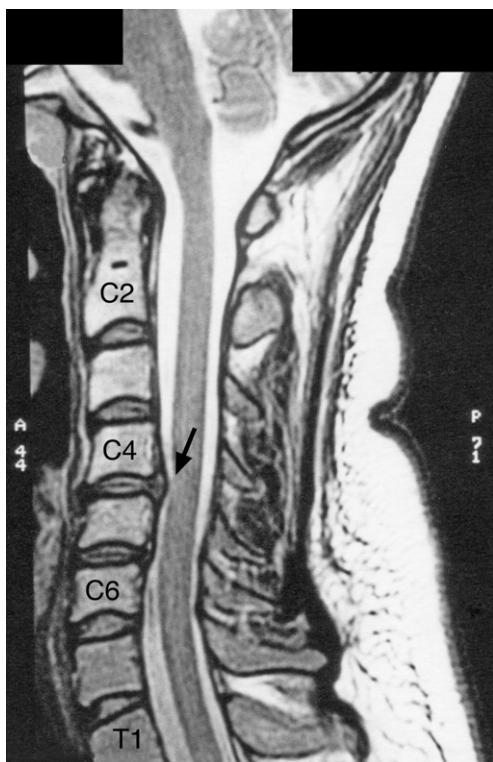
Cervical spine MRI sagittal T2-weighted image. In this sagittal section note the 'disc pathology at C4-5 and C5-6 with some bulging of both discs and early osteophyte formation'. At the C4-5 level the posterior disc bulge/protrusion is in close proximity to the anterior surface of the spinal cord itself (arrow), let alone the considerable pressure exerted upon the pain sensitive anterior part of the thecal sac/dural tube at this level. Note the associated loss of normal cervical spine contour with, in fact, a kyphosis.
